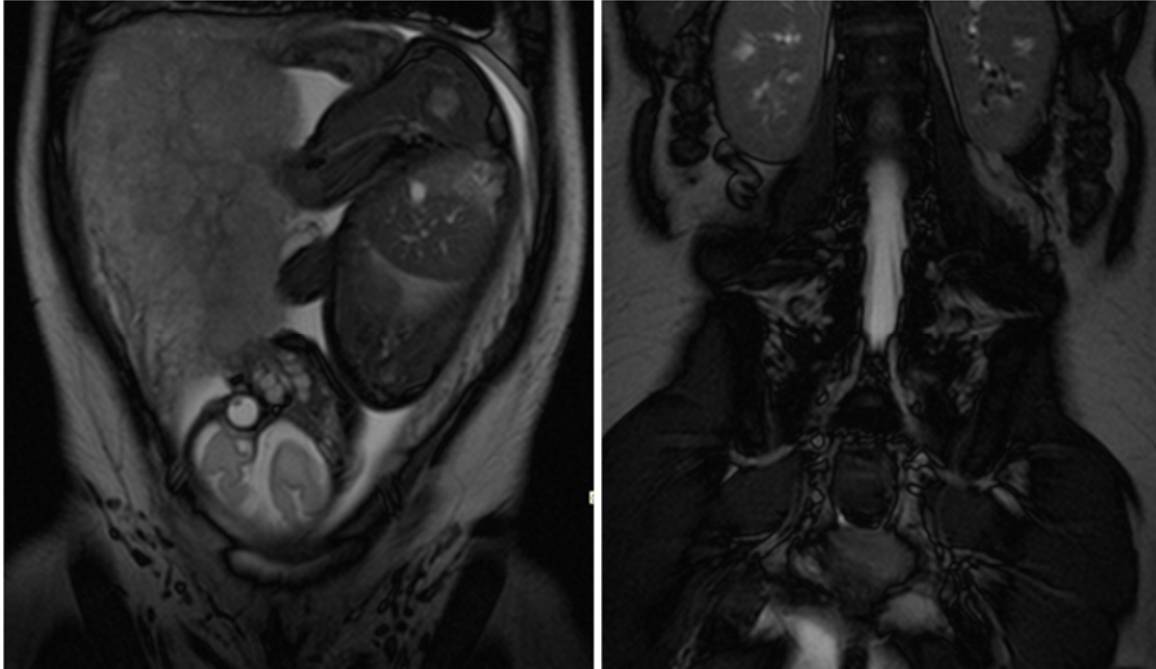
MRI images from 36 week pregnancy
